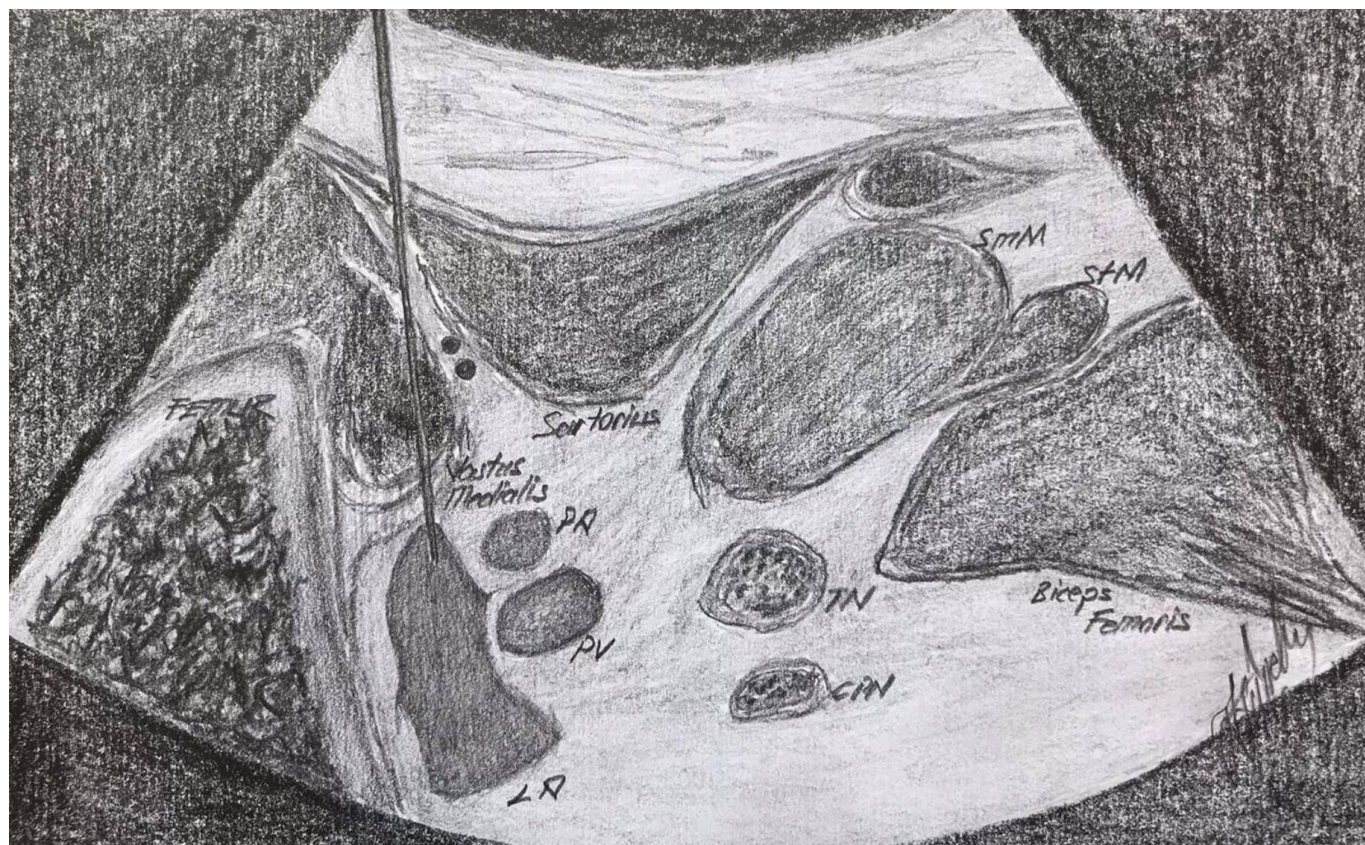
IPACK block; Reverse Ultrasound Anatomy. SmM, semimembranosus muscle; StM, semitendinosus muscle; PA, popliteal artery; PV, popliteal vein; TN, tibial nerve; CPN, common peroneal nerve; LA, local anaesthetic.
